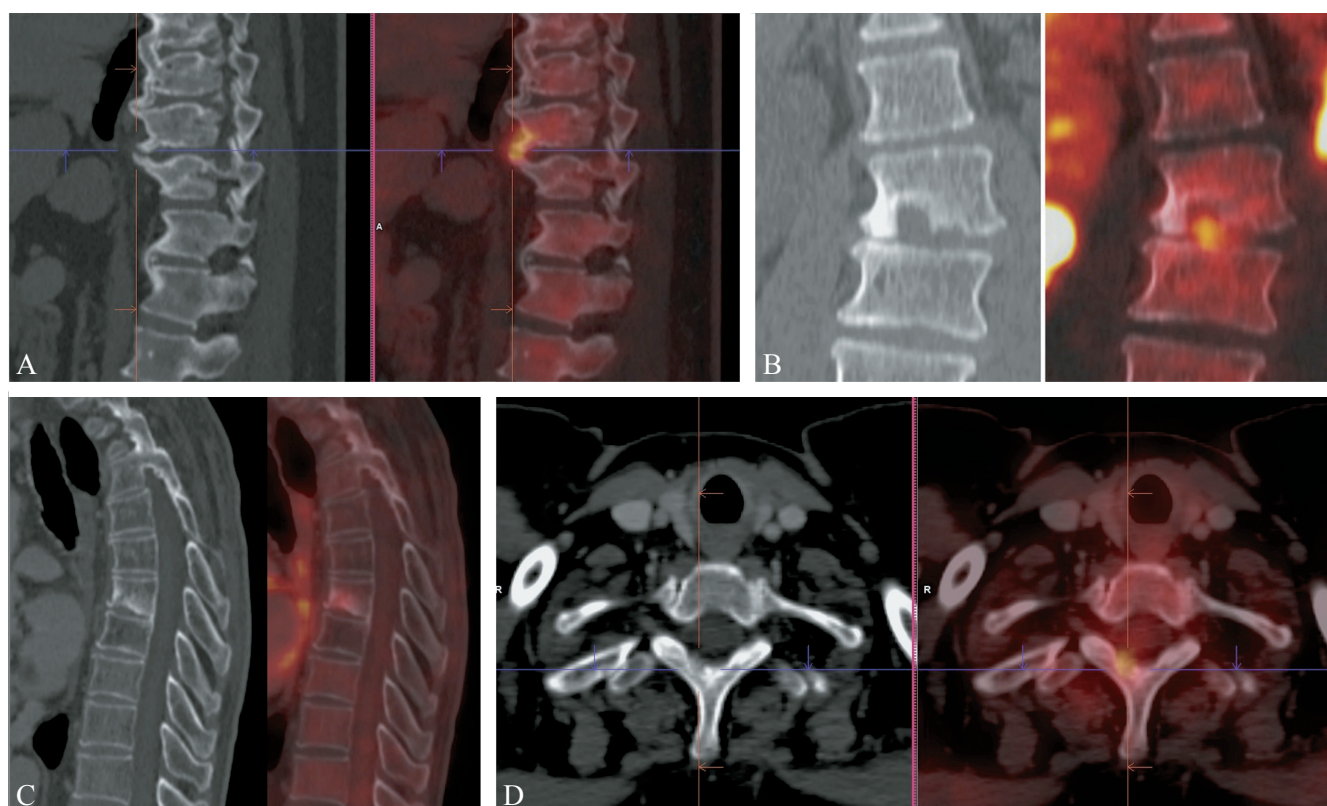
A) Sagittal CT (left) and sagittal fused images (right) demonstrate an intense focus of increased ^{18}F -FDG uptake in the dorsolumbar spine corresponding to a T12-L1 osteophytic conflict. B) Coronal CT (left) and sagittal fused images (right) demonstrate focal metabolism corresponding Schmorl's nodes (modified from Kloiber *et al.*).²⁵ C) Sagittal CT (left) and sagittal fused images (right) demonstrate degenerative changes, Modic I changes. D) Axial CT (left) and fused sagittal images (right) show a lytic tumor lesion in the right posterior T2 arc with well-demarcated focal hypermetabolism.
